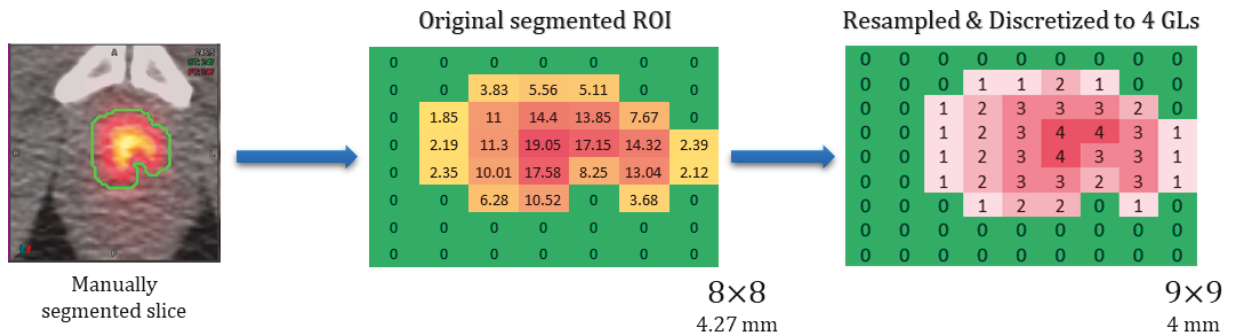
A 2D ROI over a prostate tumor on a PET image. The original segmented ROI has SUV values (middle matrix) with a certain size. The ROI is then resampled to a finer resolution and discretized with a fixed bin-size of $w_b = 5$ SUV.
